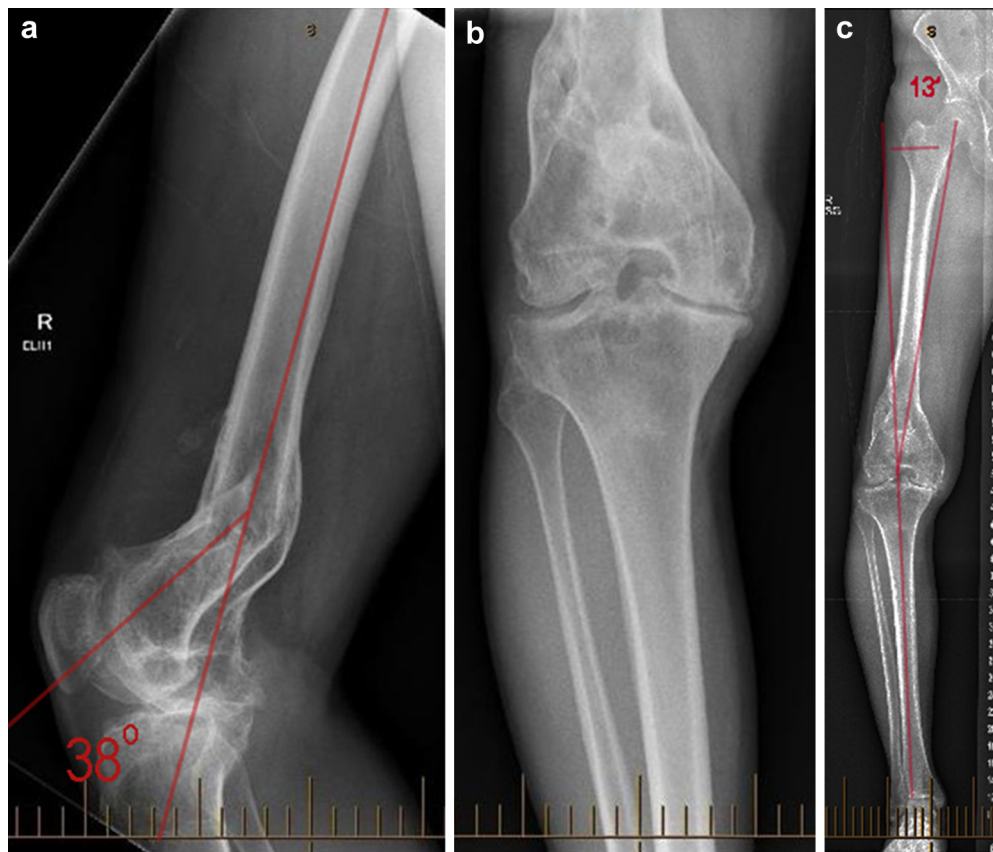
(a) A lateral radiograph of the right knee, demonstrating 38° of recurvatum, taken preoperatively. (b) An anterior-posterior radiograph of the right knee taken preoperatively. (c) A long-leg standing anterior-posterior radiograph taken preoperatively, demonstrating 13° varus alignment.
